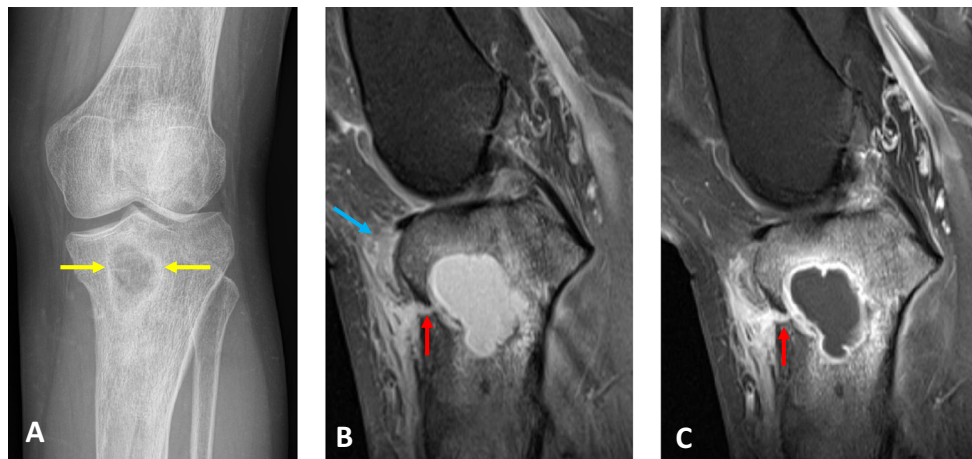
A 34-year-old female with Brodie's abscess. Frontal knee radiograph (a) demonstrates a lucent lesion in the proximal tibial metaphysis with a sclerotic margin (yellow arrows). Sagittal proton-density weighted MR (b) and T1-weighted post-contrast MR (c), both with fat suppression, demonstrate a peripherally enhancing intra-osseous
